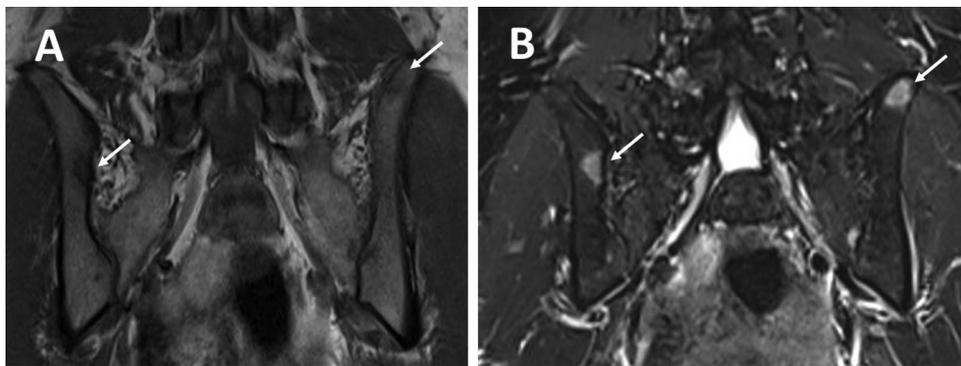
MRI coronal sequences demonstrating T1 hypo intensity (A) and STIR hyper intensity (B) pelvic lesions.
